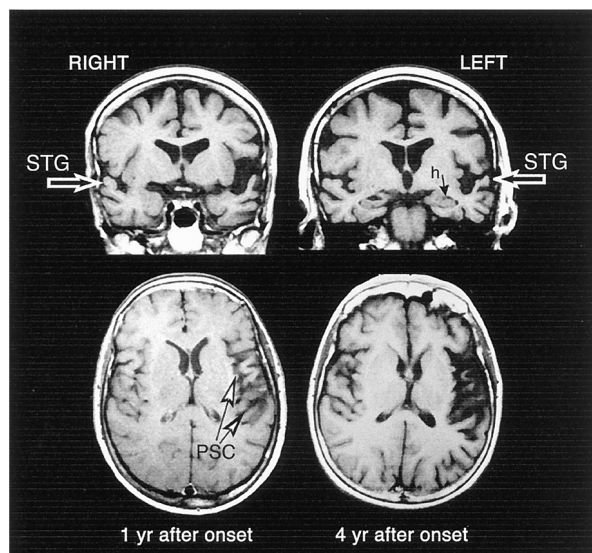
(Top) Coronal sections of T1-weighted magnetic resonance imaging (MRI) obtained 6 years after disease onset in a patient who developed primary progressive aphasia (PPA) at the age of 60 years. There is a high level of specificity in the distribution of atrophy. The left superior temporal gyrus (STG) is very atrophic and the left Sylvian cistern is enlarged, whereas the hippocampus (h) shows no atrophy. (Bottom) Horizontal sections of T1-weighted MRI obtained 1 and 4 years after onset in a patient who developed PPA at the age of 61 years. There is a clear progression of atrophy, predominantly within the left perisylvian cortex (PSC).
